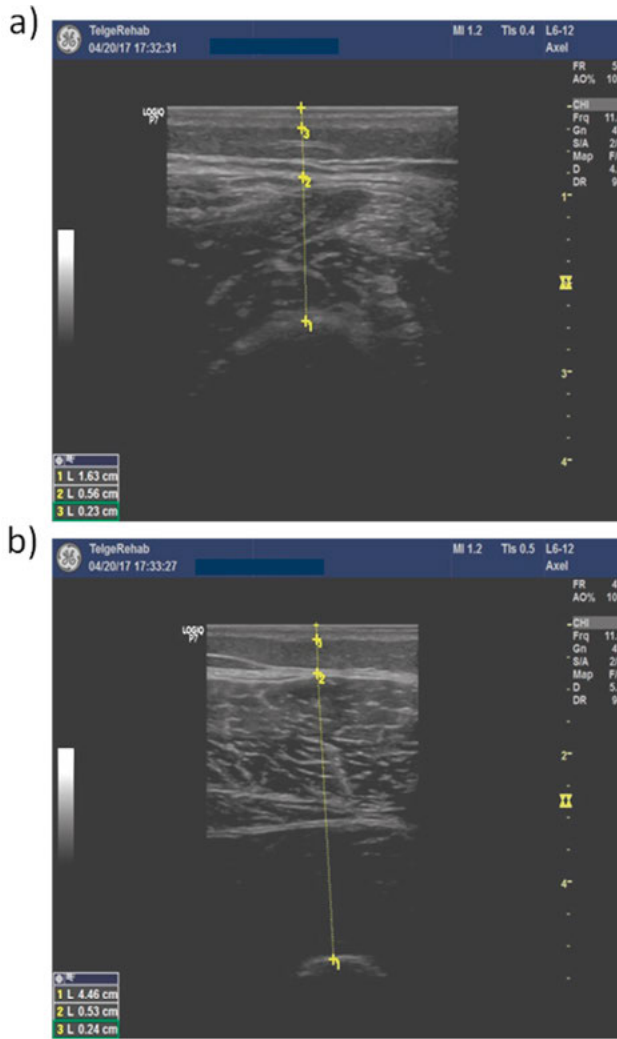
Measurement of tissue thickness of a volunteer performed using an ultrasound tool. a) Anterior of the distal femur 3 cm above the patella. b) Anterior of the thigh (10 cm above the patella) midlength. © 2018 Sensors. Reprinted, with permission, from [Mohd Shah, S.R., Velander, J., Mathur, P., et al. Split-ring resonator sensor penetration depth assessment using in vivo microwave reflectivity and ultrasound measurements for lower extremity trauma rehabilitation, Sensors, Feb. 2018].⁹⁴
